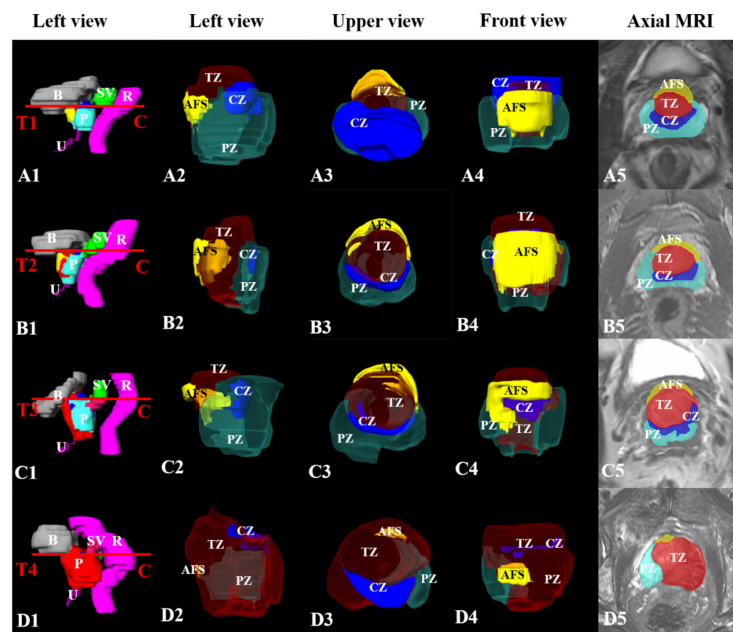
Anatomic morphology, three-dimensional shape, and spatial relationship of prostatic zones in different tumor stages. Column A1–D1, three-dimensional reconstruction of the prostate and adjacent structures in the left view. Column A2–D2, A3–D3, and A4–D4, three-dimensional reconstruction of the PZ, TZ, CZ, and AFMS in the left, upper, and front view, in which the PZ and TZ are semi-transparent. Column A5–D5, PZ, TZ, CZ, and AFMS segmentation in axial magnetic resonance imaging. Row A1–A5, T1 PCa; row B1–B5, T2 PCa; row C1–C5, T3 PCa; row D1–D5, T4 PCa. PCa, prostate cancer; PZ, peripheral zone; TZ, transition zone; CZ, central zone; AFMS, anterior fibromuscular stroma; B, bladder; SV, seminal vesicle; R, rectum; U, urethral canal; P, prostate.
